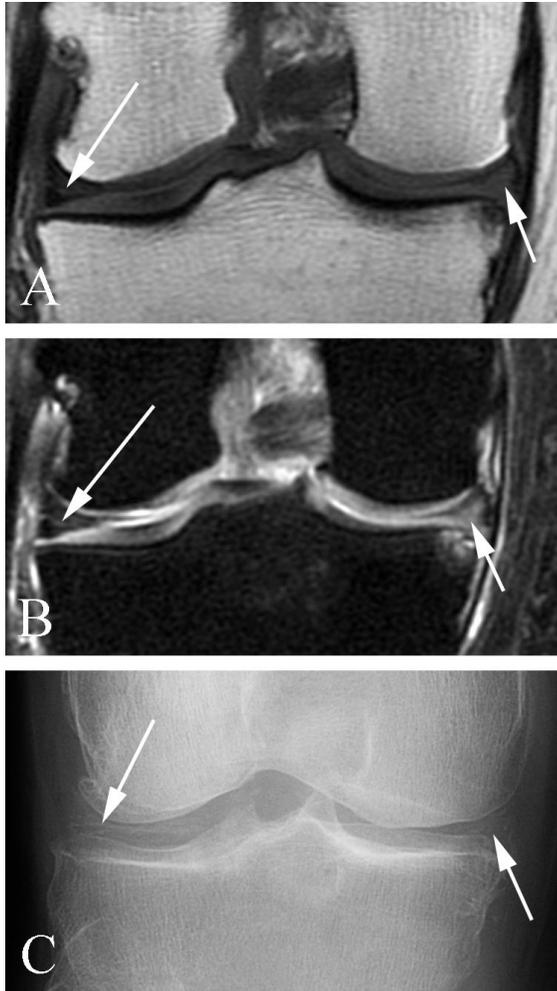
Chondrocalcinosis in a 71 year old woman with chronic knee pain, not seen on MR. A. Coronal proton density image shows mildly increased signal intensity in the menisci (arrows). B. Coronal fat-suppressed T2 weighted image also demonstrates increased signal intensity in the menisci (arrows). C. AP plain film examination shows extensive chondrocalcinosis (arrows).
